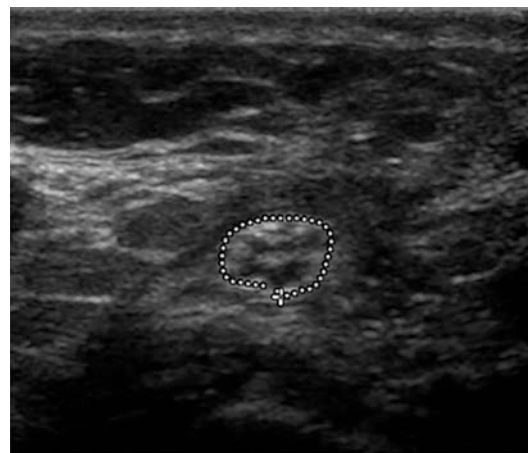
Cross-sectional ultrasound view of the ulnar nerve (encircled by cursors) at the level of the cubital tunnel showing the characteristic fascicular pattern
